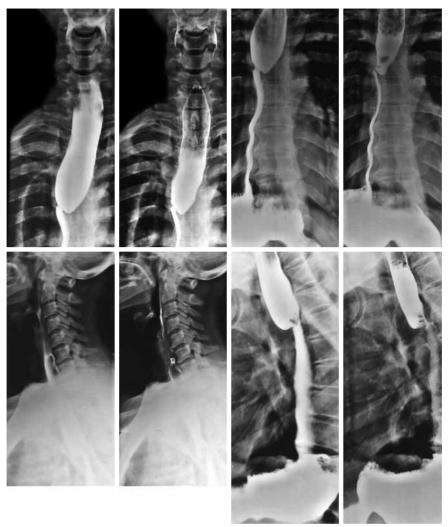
Barium X-ray shows a stenosis in a 59-year-old female patient.
